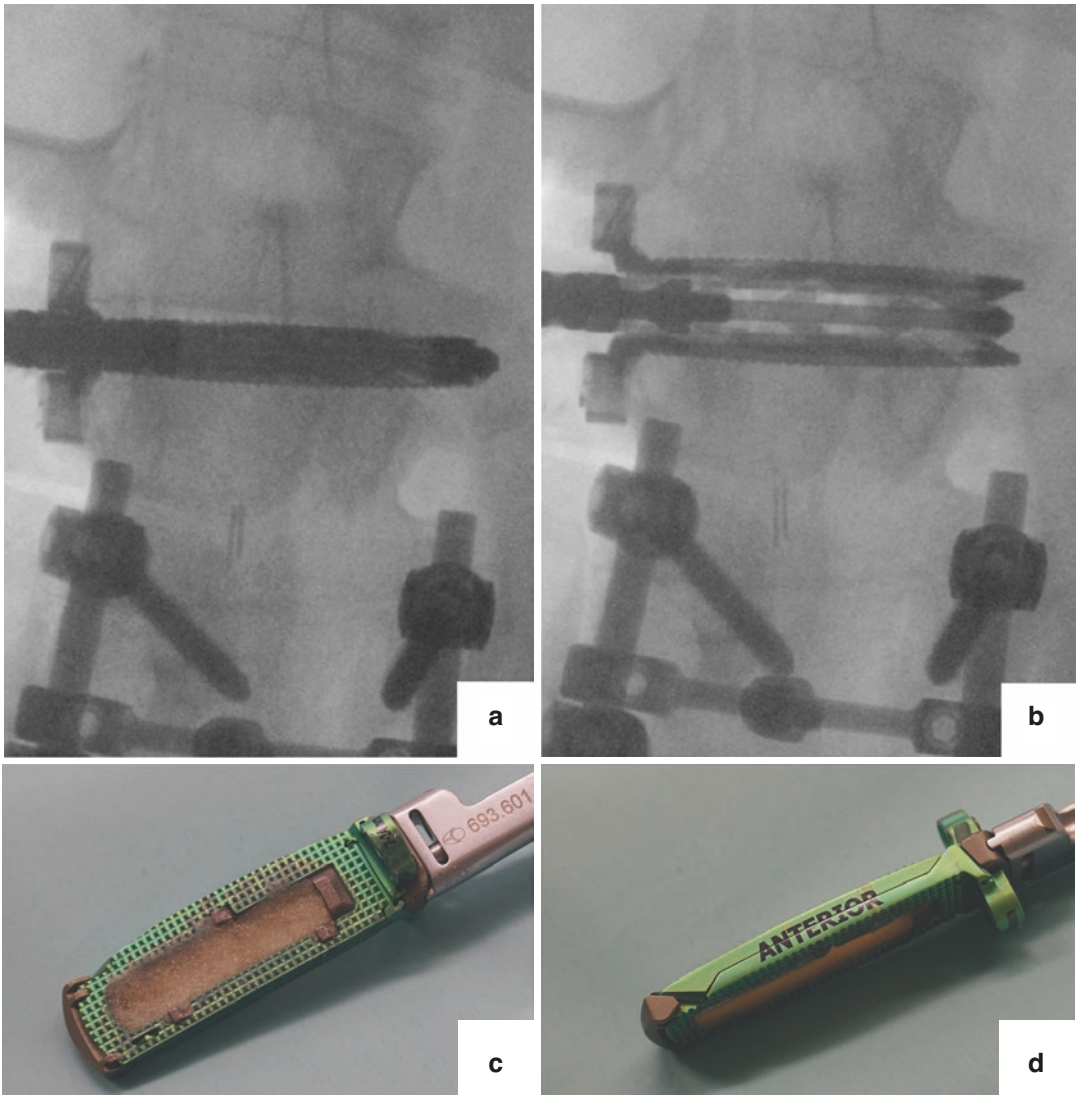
(a) X-ray image showing an interbody expandable cage (ELSA®-ATP, Globus Medical, Audubon, PA) inserted at level L3-L4, (b) the cage is expanded under fluoroscopic control, (c, d) the expandable cage filled with bone expander
